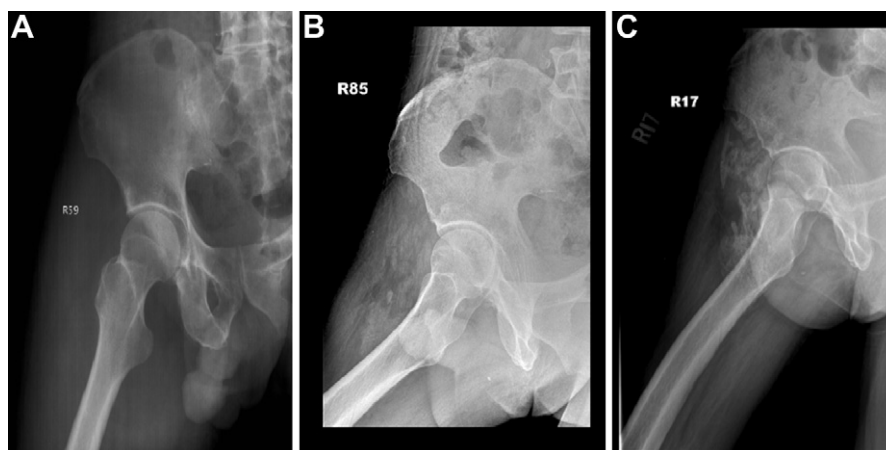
(A) Right hip radiograph, anteroposterior view taken on the date of symptom onset, no focal bony or joint lesion was shown; (B) 2 weeks after symptom onset, there was no evidence of ectopic bone formation, although there seemed to be heterogeneous soft tissue density around the hip; (C) 3 months after symptom development, the radiograph showed varying-sized amorphous ossified shadows over the anterolateral periarticular area of the right hip joint.
